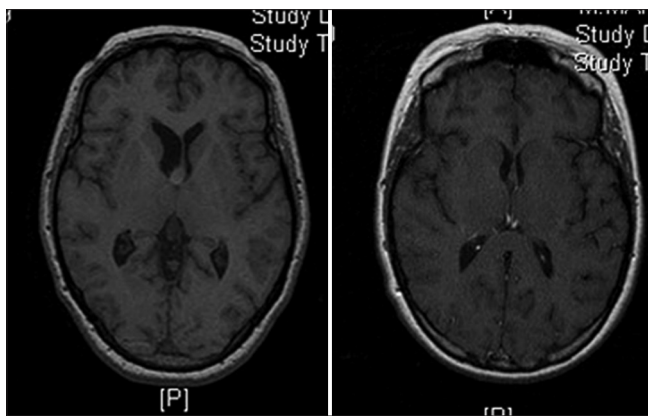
Coronal T1 MR images with gadolinium of patient #2. Left: Discovery MRI showing the 12-mm colloid cyst lesion at the anterosuperior aspect of the third ventricle. Right: 4-year post-aspiration and radiosurgery MR images demonstrating only the colloid cyst capsule remnants
